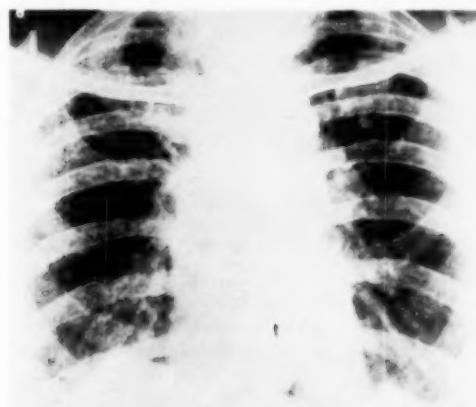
Our first x-ray film of Twin B taken in December, 1947, reveals a generalized fibrosis of both lungs.
